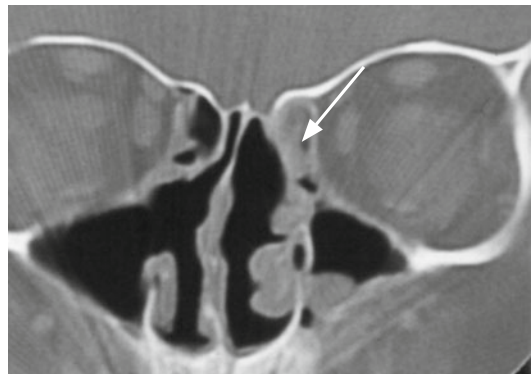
CT scan of ethmoid sinus opacity (arrow)
